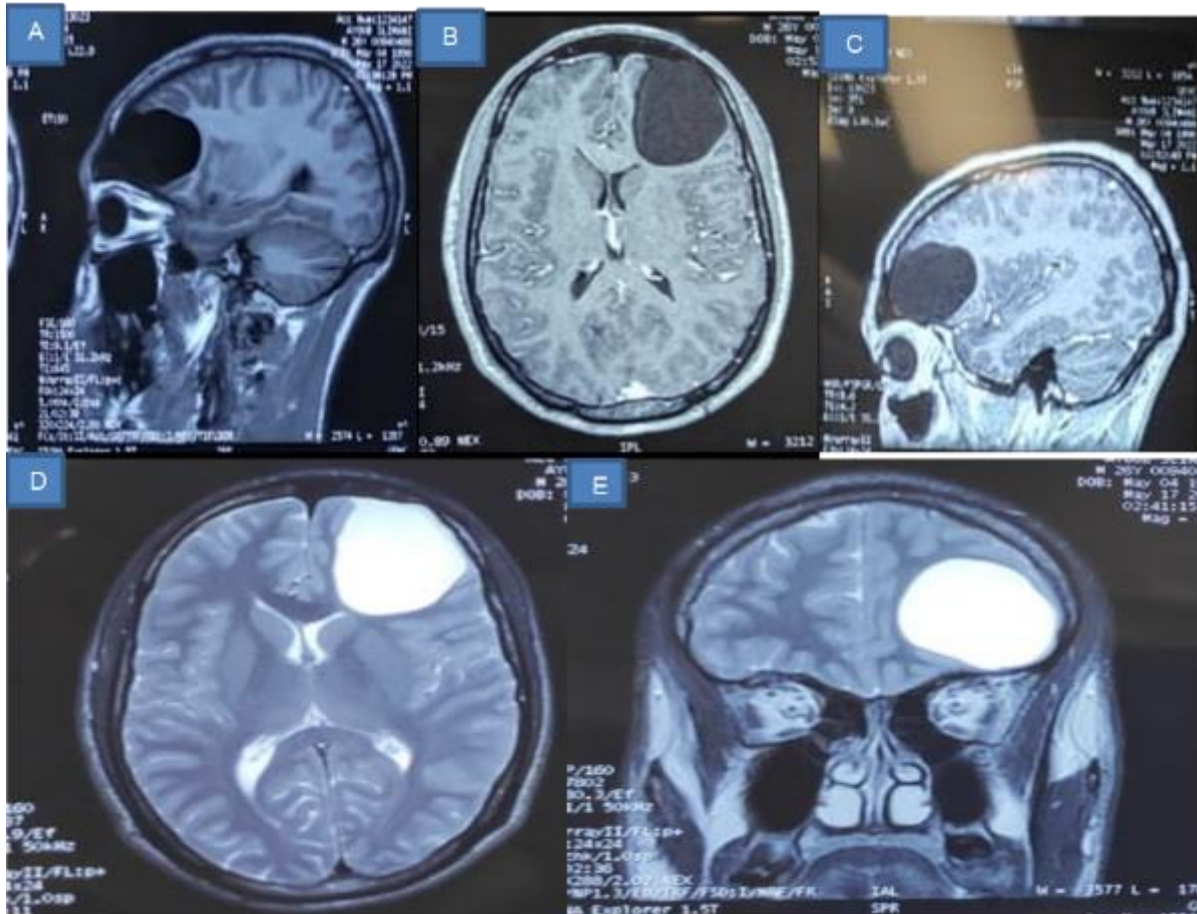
Sagittal T1-weighted (A) MRI demonstrating a well-defined hypointense cystic mass without surrounding edema. The cystic wall does not show contrast enhancement. Gadolinium-enhanced axial (B) and sagittal (C) T1-weighted. MRI signals appears hyperintense on T2-weighted sequences, and it demonstrate signal characteristics similar to CSF (D)/axial and (E) /coronal view.
